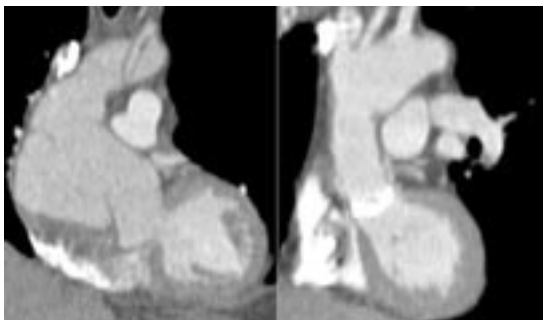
Oblique reformatted images from contrast-enhanced, cardiac-gated CT before (left) and after (right) surgical aortic root repair with aortic valve replacement in a patient who initially presented with acute aortic syndrome and had a type A acute aortic dissection with aneurysmal dilatation of the aortic root.
